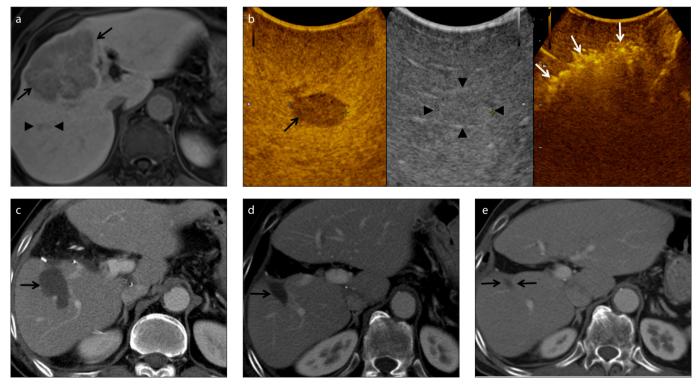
a-e. A 71-year-old man presented with intrahepatic cholangiocarcinoma (ICC). Gadoxetic acid-enhanced image (a) during hepatobiliary phase using a T1 VIBE sequence shows an 8.2 cm, soft tissue mass (arrows) in the hepatic segments IV, V, and VIII. A 2.1 cm, hypointense daughter nodule (arrowheads) is also found in segment VII. Extended right hemihepatectomy was planned, but central bisegmentectomy with intraoperative radiofrequency ablation (IORFA) was performed because of high risk of hepatic insufficiency for isolated resection. During IORFA, Sonazoid-enhanced US image (b) shows a clearly delineated nodule (arrow) in the liver that had a correlation with an ill-defined isoechoic nodule (arrowheads) on gray-scale ultrasound. Intraoperative ultrasound image obtained 12 minutes after the RFA shows successful ablation with sufficient margin (white arrows). Contrastenhanced axial CT image (c) in portal phase obtained 1 month after the central bisegmentectomy with IORFA shows surgical removal of the main mass and complete ablation of the daughter nodule (arrow). CT image (d) obtained 10 months after IORFA shows reduced RFA zone (arrow) without a viable portion. CT image (e) 7 years following IORFA shows no suspicious enhancement within the extremely reduced ablated zone (arrows). The patient has been doing well for 96 months without tumor recurrence or distant metastasis.
